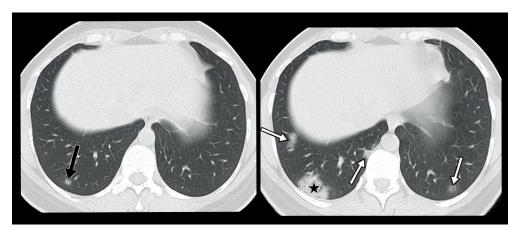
A 34-year-old female patient. Initial chest CT demonstrates a small nodule of ground-glass density (black arrow) in the right lung. Follow-up chest CT demonstrates bilateral areas of ground-glass density (white arrows) and an area of pulmonary consolidation (asterisk) in the right lung.
